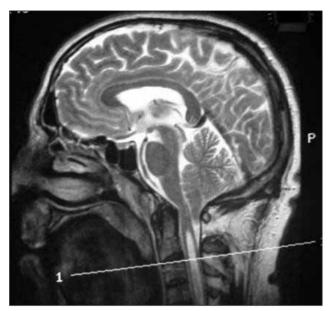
Midsagittal T2-weighted MRI before decompression. The line drawn through the region of interest at the syrinx indicates the plane where the subsequent phase-contrast axial images are taken.
